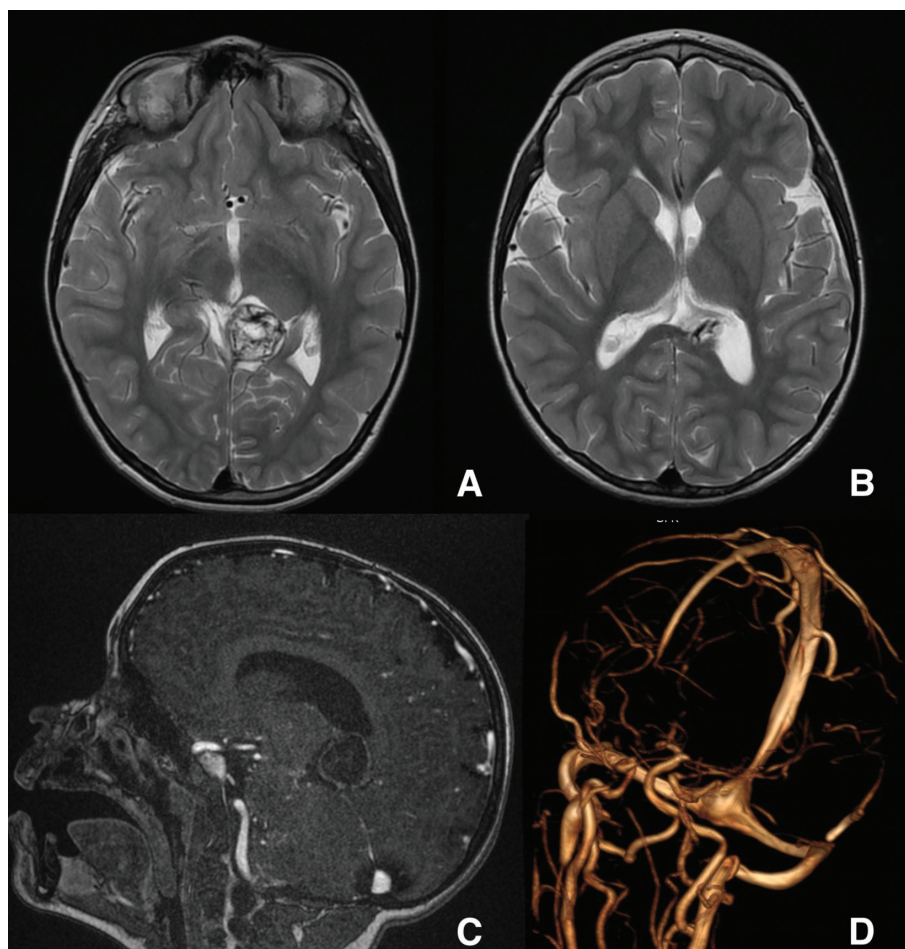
MRI at 8 years. Again, axial T2 and contrast MR angiography demonstrate complete occlusion of the VGAM without any abnormal finding in the brain parenchyma (A, B, C, D).
